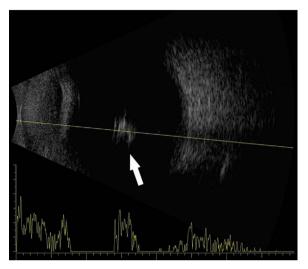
B-scan ultrasonography of the left eye: the arrow indicates the IOFB (arrow) in the posterior segment.
